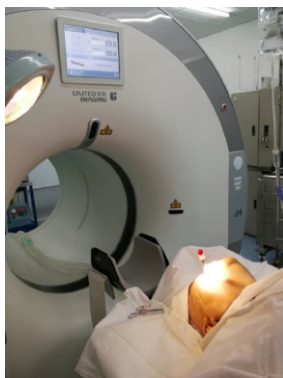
Target confirmation by a computed tomographic scan.
